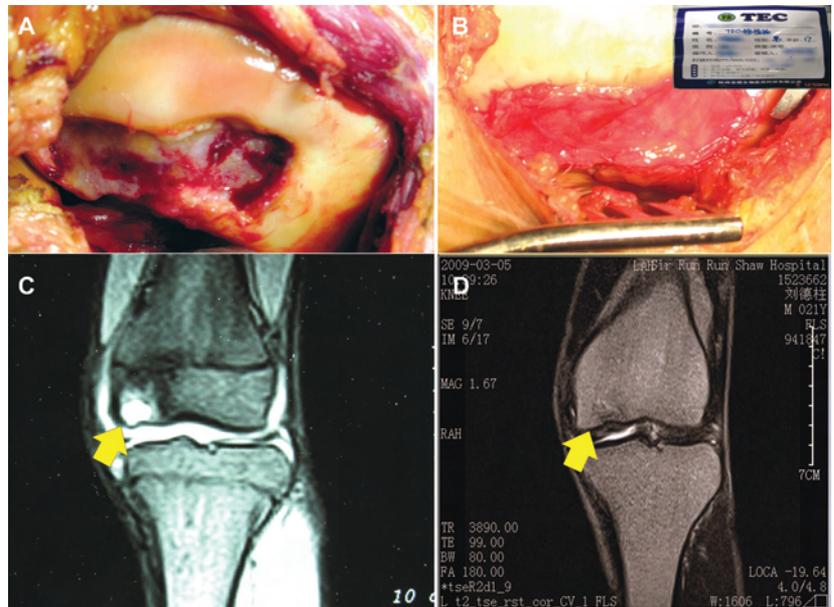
Large chondral defects of the knee were treated by tissue engineered cartilage (TEC) transplantation. (A) A 19-year-old male with 4.8 x 2.5 cm knee cartilage defect. (B) TEC transplantation. (C) Presurgery MRI image of knee. (D) 14 months postsurgery MRI image of knee after TEC transplantation. (The arrows indicate the cartilage defect area.)
